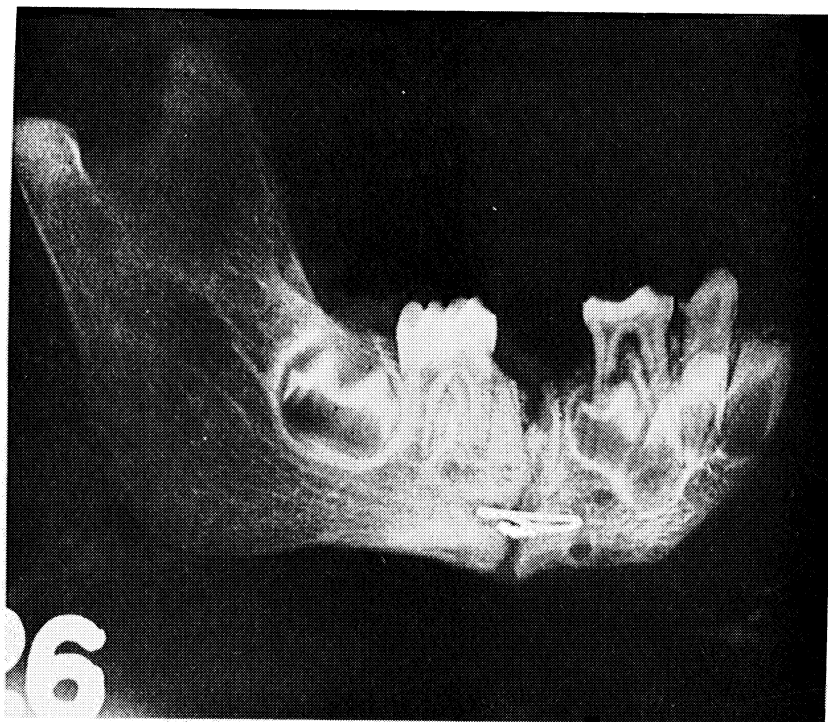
Lateral jaw radiograph of an eight-week clinical union operated extraorally. There is excellent approximation, little submandibular callus and apparent bony bridging of the fracture defect.
